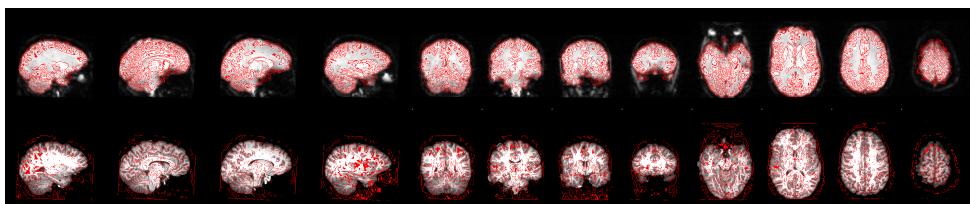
Registration of the functional MRI data of run 2 to the structural MRI data using full search & 12 DOF
